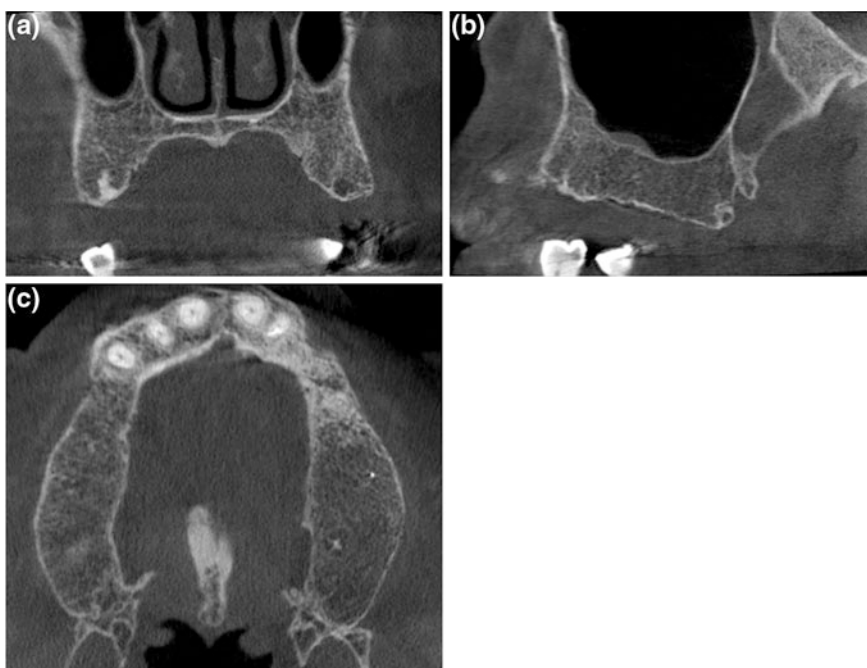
Preoperative CBCT: coronal (a), sagittal (b) and axial (c) scans showing partially edentulous maxilla
